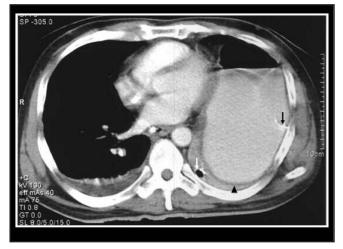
Contrast enhanced CT thorax shows dilated stomach with air-fluid level located intrathoracic. The stomach is no longer supported posteriorly by the left diaphragm and fall to dependent position against the posterior ribs (dependent viscera sign) (black arrowhead). Part of the gastric tube (black arrow) is seen within the stomach. Chest tube is seen posterior to the herniated stomach (white arrow).
